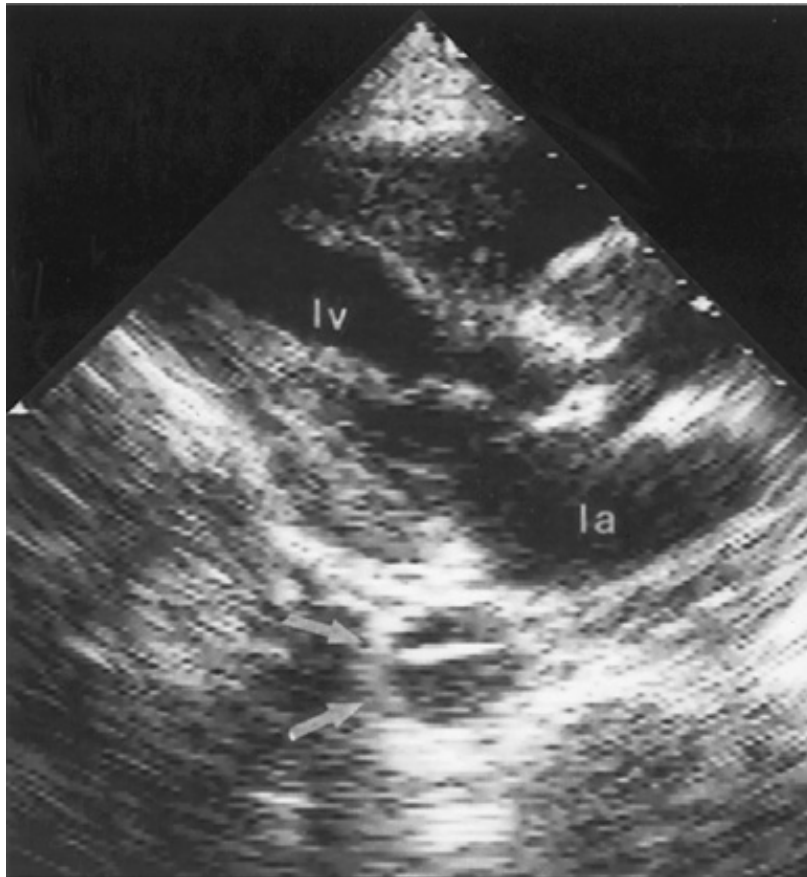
Transthoracic parasternal long-axis plane demonstrating a dissection of the descending thoracic aorta. The aortic root is dilated, the aortic valve is thickened, and an intimal flap is present in the descending aorta (*arrows*). LV = left ventricle; LA = left atrium.
